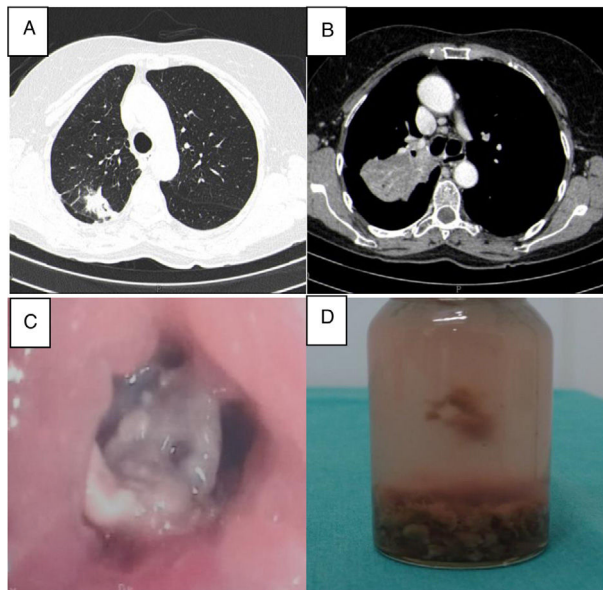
(A and B) Computerized tomography (CT) of the chest showed a nodular image with a diameter of 24 mm and atelectasis of the posterior segment of the right upper lobe; (C) flexible bronchoscopy revealed total obstruction of the posterior segment of the right upper lobe by amorphous material with abundant granulation tissue; (D) macroscopic appearance of the aspirated material was compatible with rice grains.
